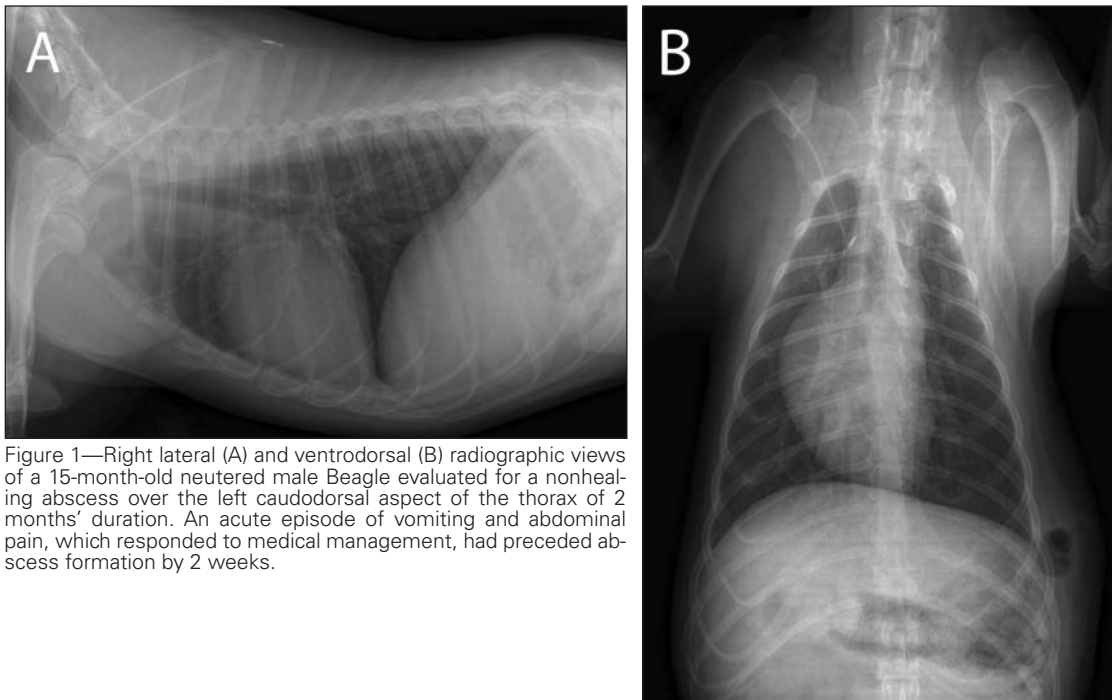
Right lateral (A) and ventrodorsal (B) radiographic views of a 15-month-old neutered male Beagle evaluated for a nonhealing abscess over the left caudodorsal aspect of the thorax of 2 months' duration. An acute episode of vomiting and abdominal pain, which responded to medical management, had preceded abscess formation by 2 weeks.
